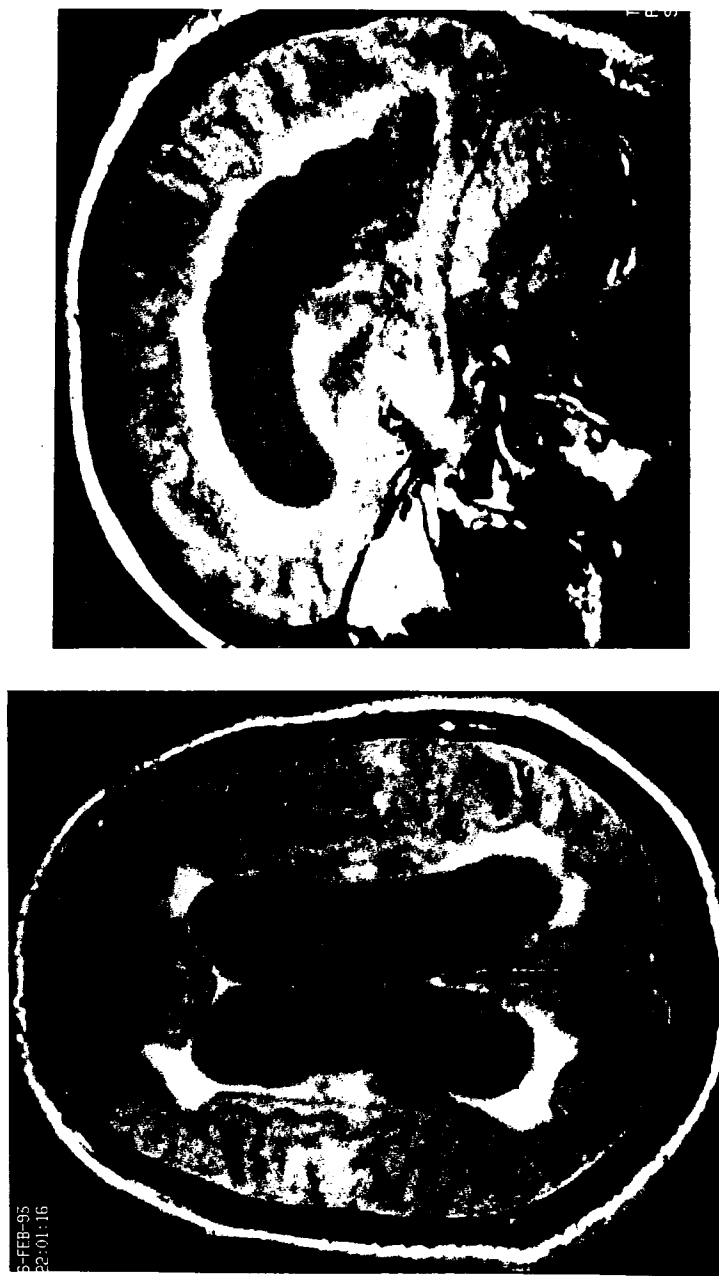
MRI brain scans of Case B showing marked generalised ventricular dilatation and periventricular high signal without significant cerebral atrophy.
